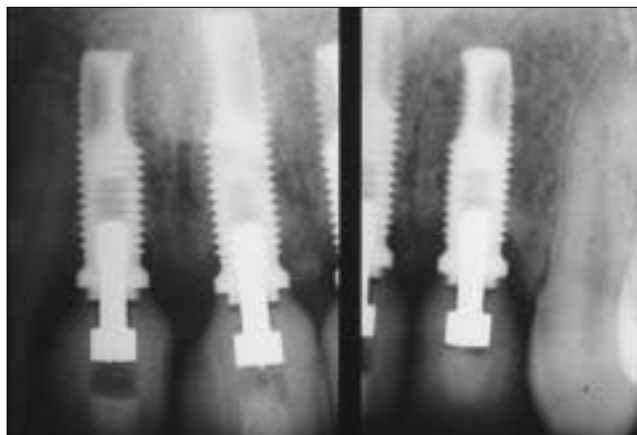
Periapical radiographs: Implants 11, 21, 22, screw-retained ceramic abutments (32 Ncm), Procera ceramic crowns.
